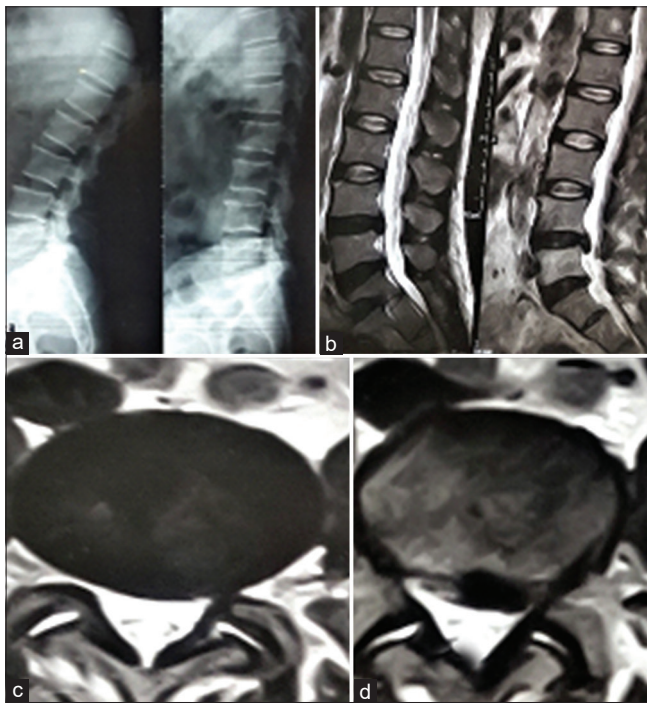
Primary discectomy done on January 11, 2014 at L 4-5 level of 46-year-old man. (a) Dynamic X-ray shows no instability (b), and (c,d) sagittal and axial view of T2W magnetic resonance imaging shows disc herniation.
